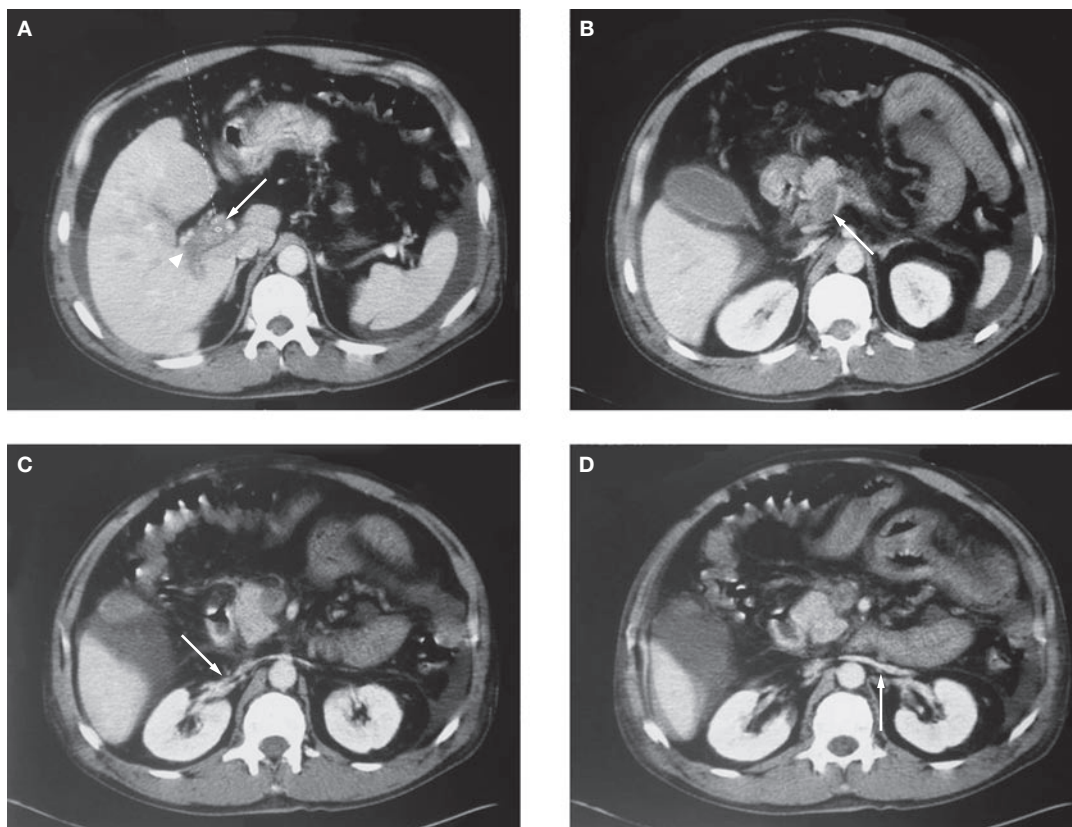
Abdominal CT scans on admission to hospital. (A) CT scan showing thrombosis in the trunk (arrow) and in the right branch of the portal vein (arrowhead). (B) CT scan showing thrombosis in the superior mesenteric vein (arrow). (C) CT scan showing the absence of thrombosis in right renal vein (arrow). (D) CT scan showing the absence of thrombosis in left renal vein (arrow).
